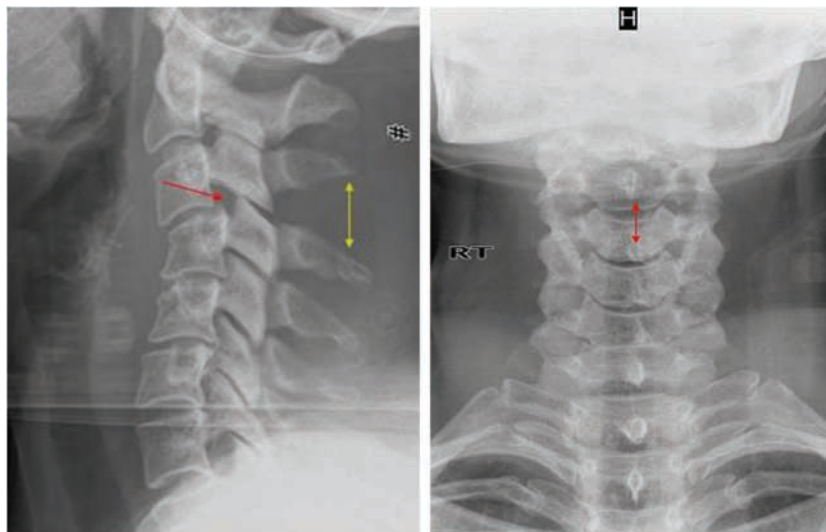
Initial screening lateral and anteroposterior radiographs. The lateral view (left) shows bilateral facet joint subluxation of C3 and C4 facet joints (red arrow) with splaying of the spinous processes between these vertebrae (yellow arrow). Increased interspinous distance can be seen in the anteroposterior view (right; red arrow)
